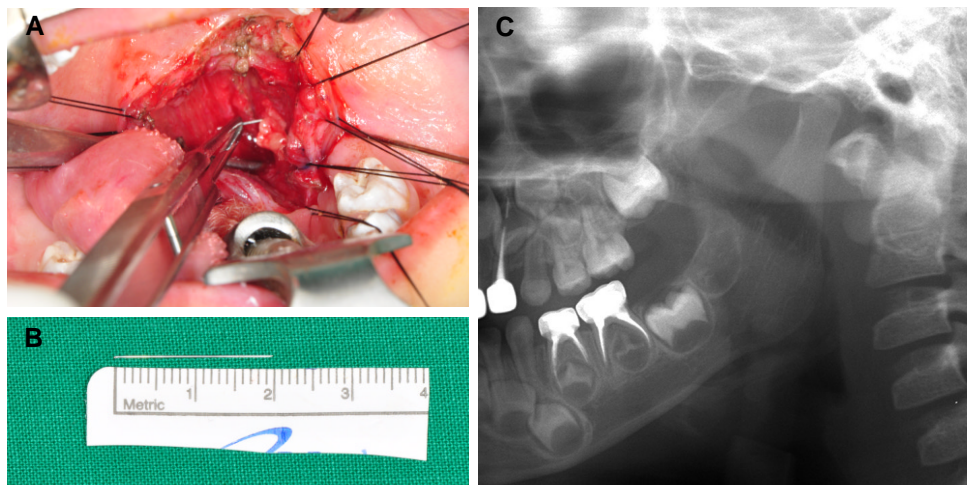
Clinical photographs and post-operative panoramic radiograph. (A) Intra-oral photograph showing the needle fragment lodged in the soft tissue. (B) The removed needle fragment. (C) Postoperative panoramic radiograph showing no residual needle fragment.
